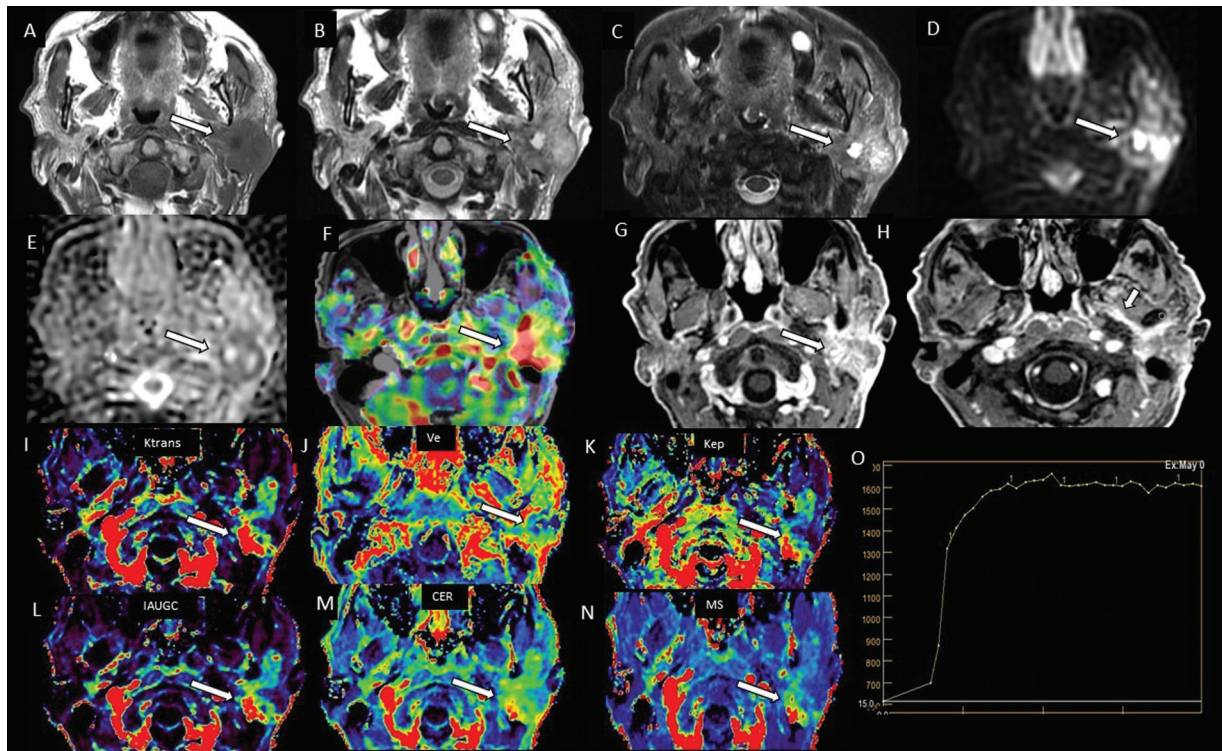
Magnetic resonance imaging (MRI) of the parotid gland in a 64-year-old man with acinic cell carcinoma of the left parotid gland. Axial (A) T1-weighted imaging (T1WI), (B) T2WI, and (C) short tau inversion recovery images show an irregular lobulated lesion with heterogeneous signal and areas of cystic change. (D) Diffusion-weighted imaging and (E) apparent diffusion coefficient show restricted diffusion. (F) Arterial spin labeling shows increased perfusion. (G, H) Postcontrast T1WI shows heterogeneous enhancement and perineural spread along the mandibular division of left trigeminal nerve. (I) Quantitative dynamic contrast-enhanced (DCE) shows a high Ktrans (0.634/min), (J) low Ve (0.54), (K) high Kep (1.23/min), (L) high IAUGC (0.554), (M) CER (1.845), and (N) high MS (0.0834). (O) On DCE-MRI, type C time-intensity curve is seen. CER, contrast enhancement ratio; IAUGC, initial area under the gadolinium enhancement concentration curve; MS, maximum slope.
